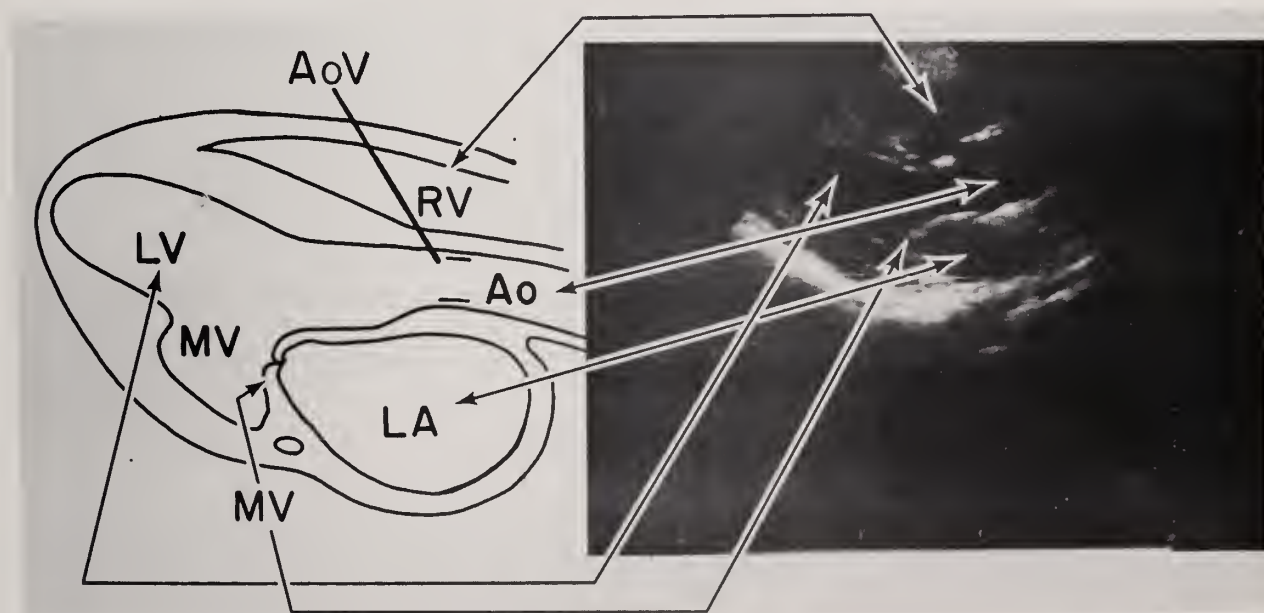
Longitudinal parasternal axial view at end of systole: RV: right ventricle, LV: left ventricle, Ao: aorta, LA: left atrium, M.V.: mitral valve, IVS: inter-ventricular septum, VSD: ventricular septal defect, AoR: aortic root.
